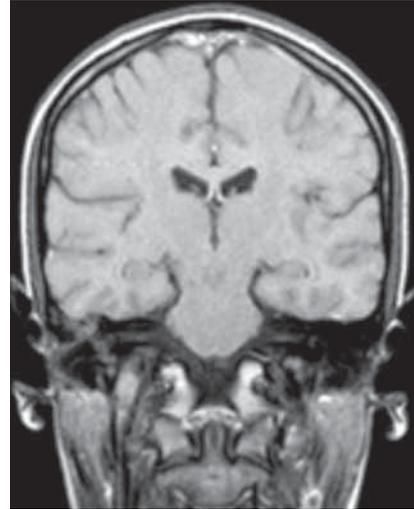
M.R.I., T1-weighted image. Hyperintense signal indicating subacute thrombosis of the S.S.S.; this pattern was found 14 days after the onset of symptoms.
